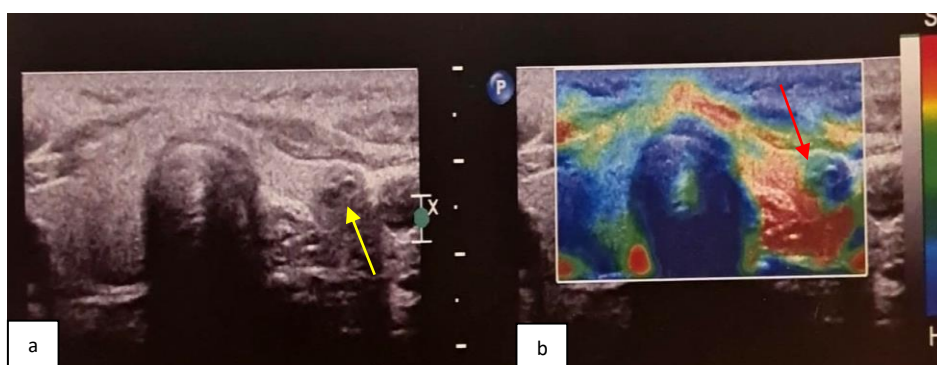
A 46 years man, has thyroid nodule, was referred for elastography; (a) a B-mode transverse sonographic examination image showed a left hypoechoic rounded thyroid nodule with cystic changes inside, measuring about 12 X 10 mm (yellow arrow) and (b) colored transverse elastography image, showed mixed green and blue colour with predominate of the green colour (red arrow), denoting soft consistency of the nodule with low strain ratio (SR) 0.6, benign nodule.
